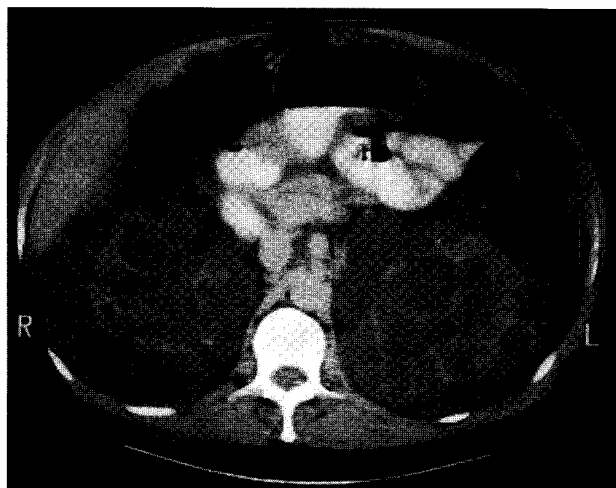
Abdominal CT scan of the patient taken after 11 years of CAPD. Both kidneys are massively enlarged and virtually replaced by multiple large and small cysts.
